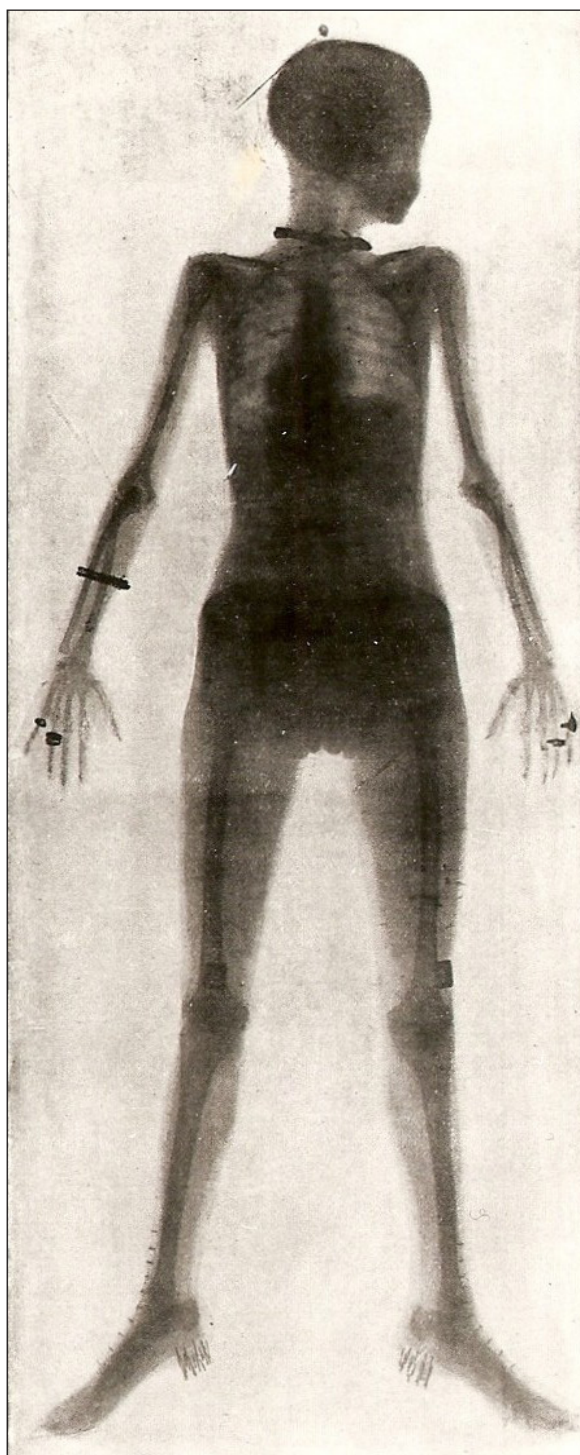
The world's first whole body radiograph taken in a single exposure [43, 44]
